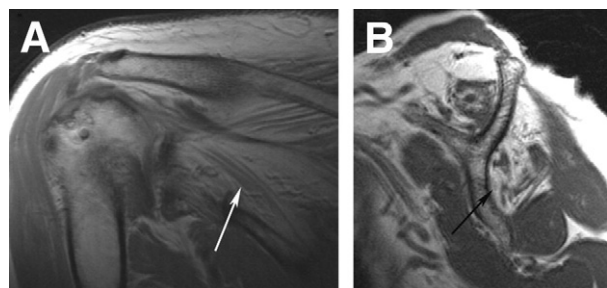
MRI scans showing fatty degeneration of greater than 75%. (A) T2-weighted coronal image with greater than 75% fatty degeneration of infraspinatus (arrow). (B) T1-weighted sagittal image with greater than 75% fatty degeneration of infraspinatus (arrow).
